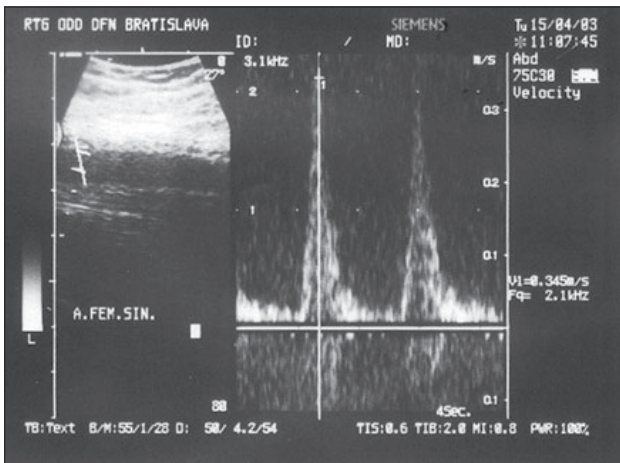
Ultrasound of arterial flow.
